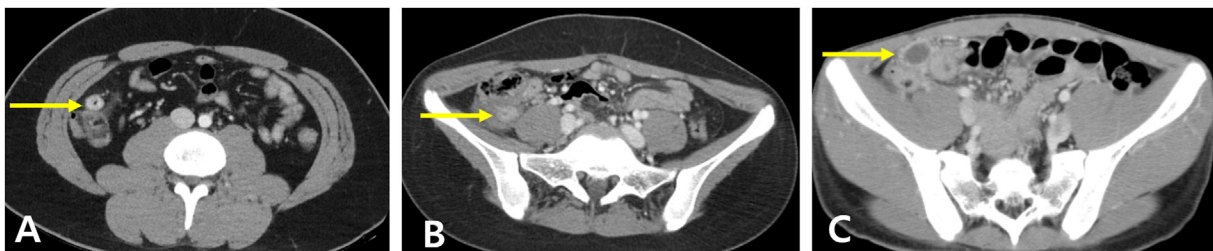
Modified Hinchey classification of abdominal CT findings (A) Stage 0: In an 18-year-old male, a calcified diverticulum (arrow) is seen with mesenteric fat infiltration adjacent to the diverticulum in the proximal ascending colon (B) Stage Ia: In a 13-year-old female, focal infiltration (arrow) is observed around the diverticulum of the proximal ascending colon, accompanied by segmental wall thickening along the ascending colon (C) Stage Ib: A 2.0 × 1.5 × 1.7 cm pericolic abscess (arrow) is associated with proximal ascending colon diverticulitis in a 14-year-old male.
